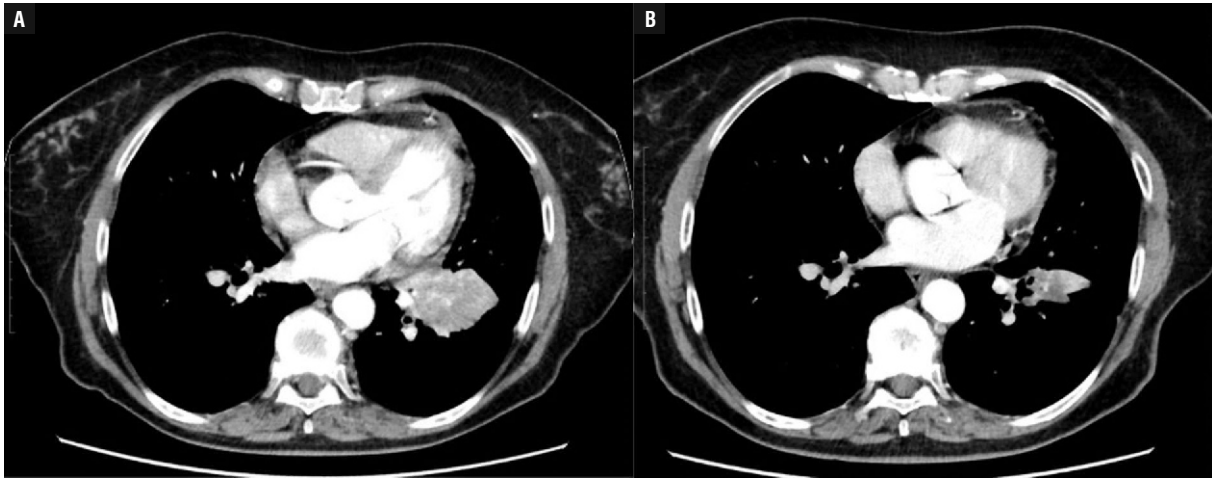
Computed tomography scans presenting partial response after 6 months of effective treatment with capmatinib
